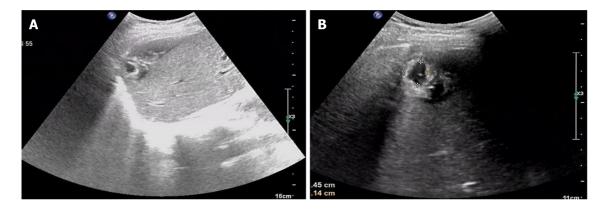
Abdominal ultrasound showed a mixed echogenic mass in the right lobe of the liver near the apex of the diaphragm. A: The mass was approximately 1.5 cm × 1.1 cm in size; B: The mass showed characteristic features of a gestational sac, with a bud of approximately 0.4 cm in length (indicated by a bright dot in the dark zone).
